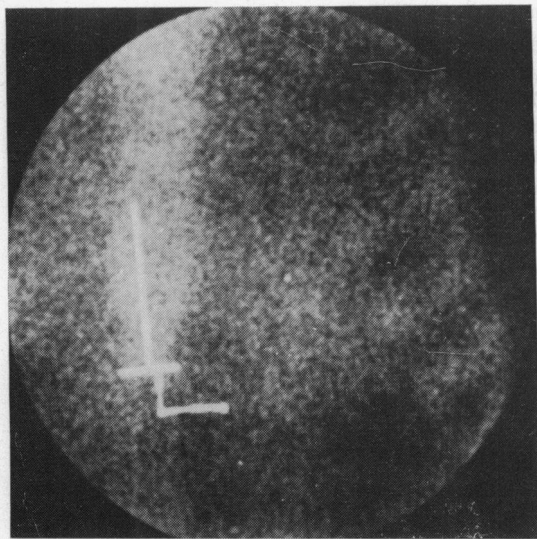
A ^{99m}Tc -PYP myocardial scintigram obtained from a patient with unstable angina pectoris. Note the faint and diffuse uptake of the ^{99m}Tc -PYP in a pattern very similar to that shown in the preceding figure in which a subendocardial infarction was present.
